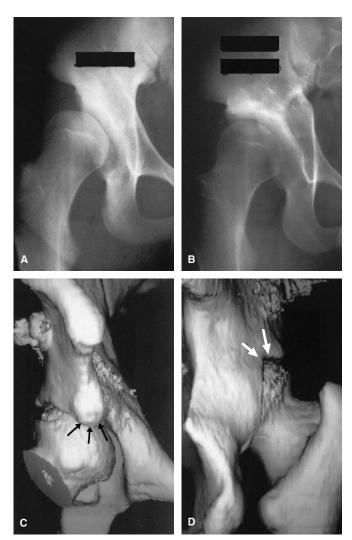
A, Preoperative AP radiograph of a 25-year-old man shows severe developmental hip dysplasia. The center edge angle was -15° . The patient had a severe hip subluxation, a slight loss of congruency, and slight arthrosis (Grade 2) limited to a severe acetabular bone condensation. B, Anteroposterior radiograph taken 15 years after Chiari pelvic osteotomy (the screw was removed for the CT scan). The patient's hip rating increased from 14 points preoperative to 18 points at the last followup. The femoral head coverage was complete without progression of arthrosis or subluxation. C, Anterior and (D) posterior three-dimensional CT scan reconstructions taken at 15 years of followup can be seen. The design of the Chiari osteotomy (dome-shaped) allowed excellent coverage of the anterior and posterior aspects of the femoral head (arrows).
